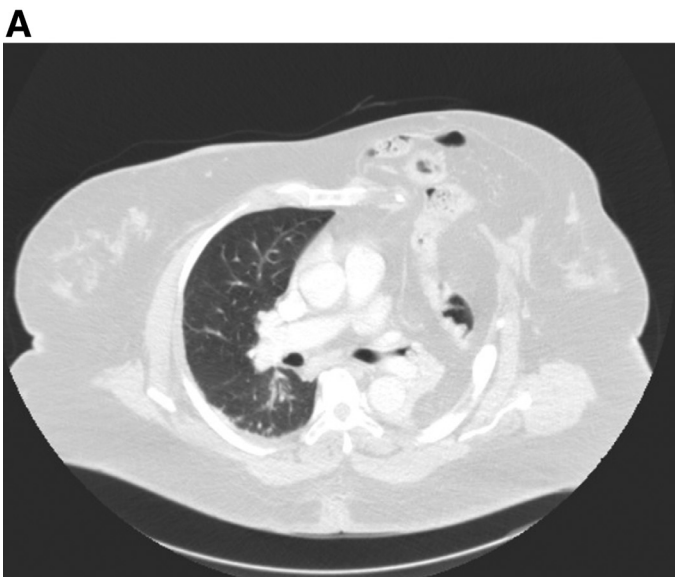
Chest CT with evidence of intra-abdominal content in the left hemithorax. (A) Lung window and (B) abdominal window.
